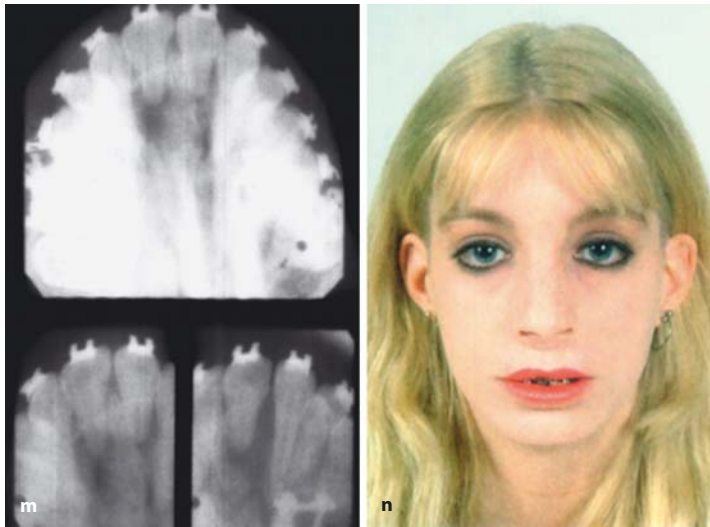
59 a–n. (continued) m Occlusal radiographs. n Postoperative frontal facial view. Comment: There was limited alveolar bone support to the lateral incisor areas. The premaxilla was mobile. Marked velopharyngeal incompetence with regurgitation of fluid while drinking and intake of air, while speaking required a palatal obturator. The surgical plan was to extract the questionable lateral incisors and reposition the maxillary lateral segments to close the lateral incisor and large anterior cleft spaces
